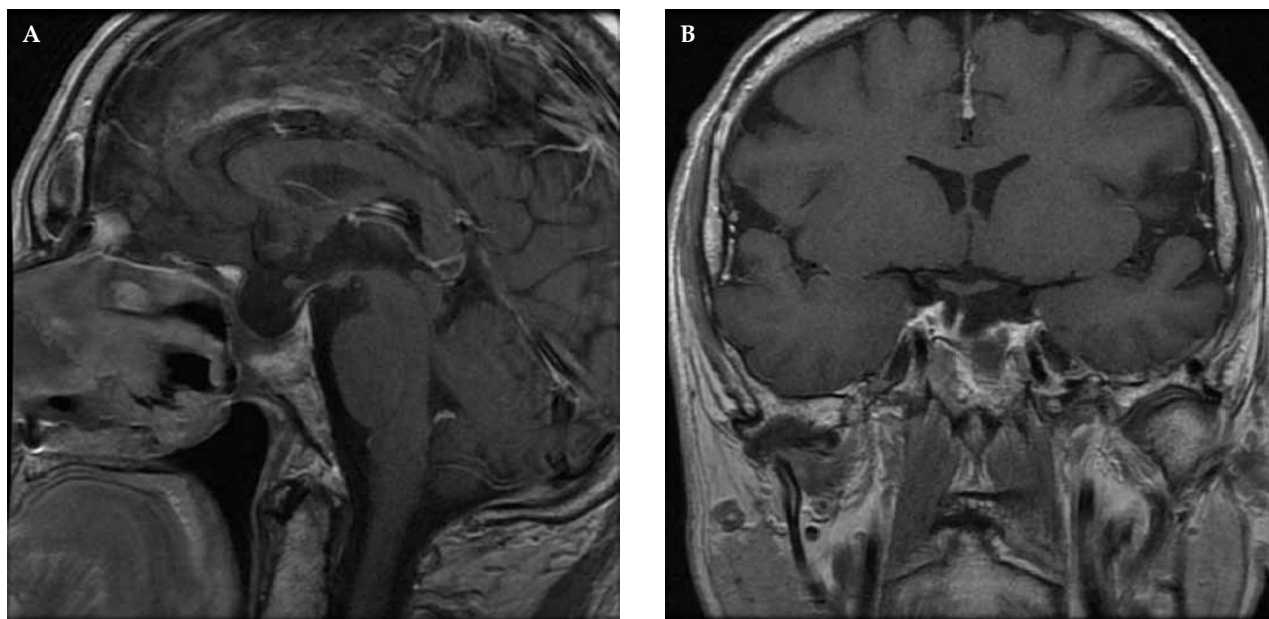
Pituitary MRI scans after successful neurosurgery of TSH-secreting macroadenoma. A. sagittal; B. coronal
